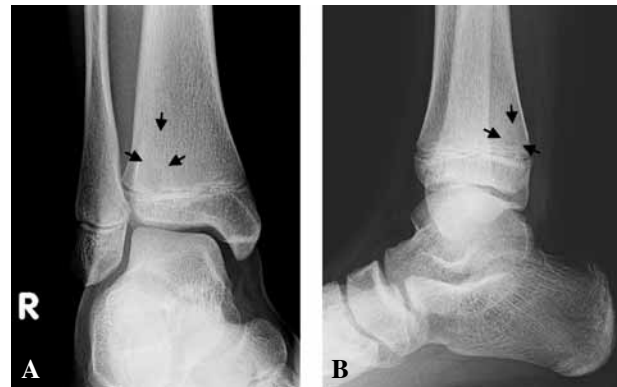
Postero-anterior and lateral radiograph of the patient's right ankle just after admission to the hospital and 4 weeks after temporary pain, swelling and erythema of the ankle is shown. The radiograph shows a subtle but circumscribed radiolucent lesion of the lateral (A) and dorsal (B) aspect of the metaphysis.
